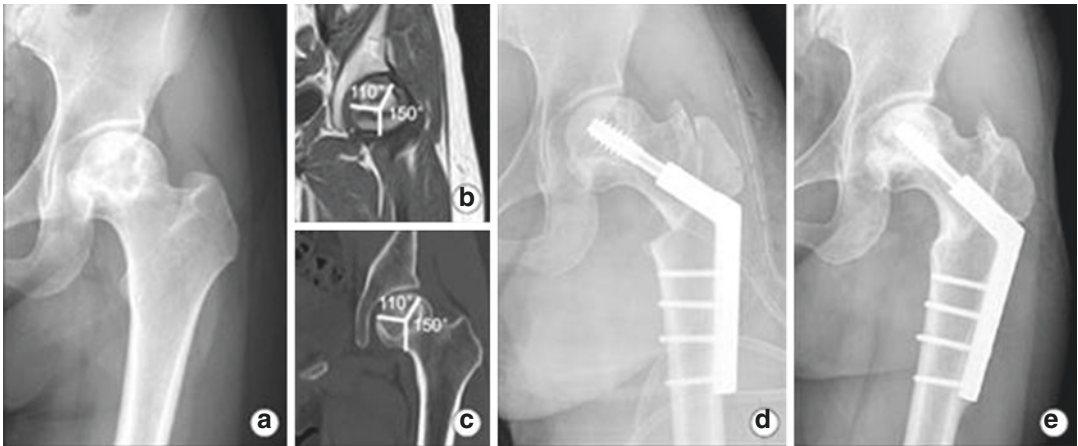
A 28-year-old woman had osteonecrosis in the left femoral head. (a) Preoperative anteroposterior hip radiograph. (b, c) The angle of the necrotic area in the mid-coronal images of computed tomography and magnetic resonance imaging was 110°. The angle between the central vertical line of the femoral head and the lateral
